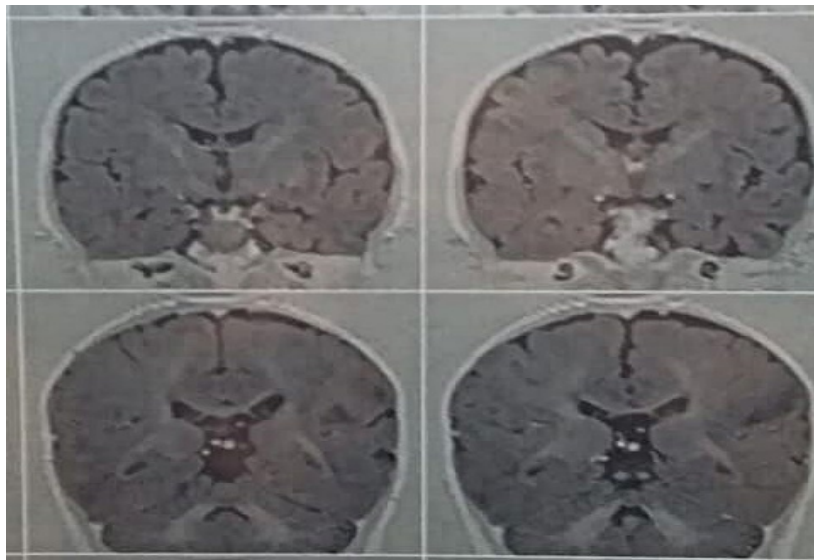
Cerebral MRI: hamartomatous nodules
